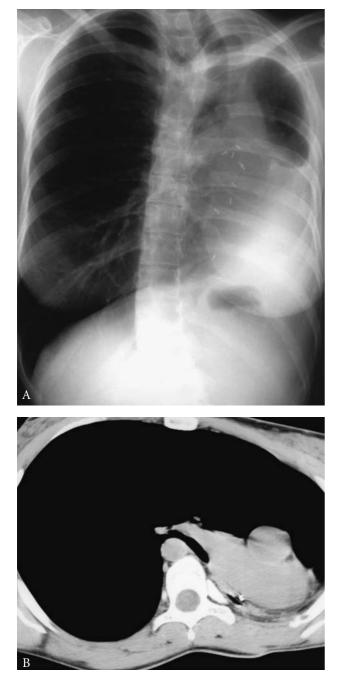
Postpneumonectomy syndrome in a 19-year-old woman, within 1 year after right pneumonectomy for bleeding from congenital cystic disease. A, Chest roentgenogram shows the heart and mediastinum displaced to the right with obliteration of right pleural space. The lung is hyperexpanded and herniated. B, Lateral roentgenogram demonstrates posterior displacement of mediastinal contents and anterior herniated lung. C, Computed tomography scan shows the left main bronchus compressed between the pulmonary artery and spine.
